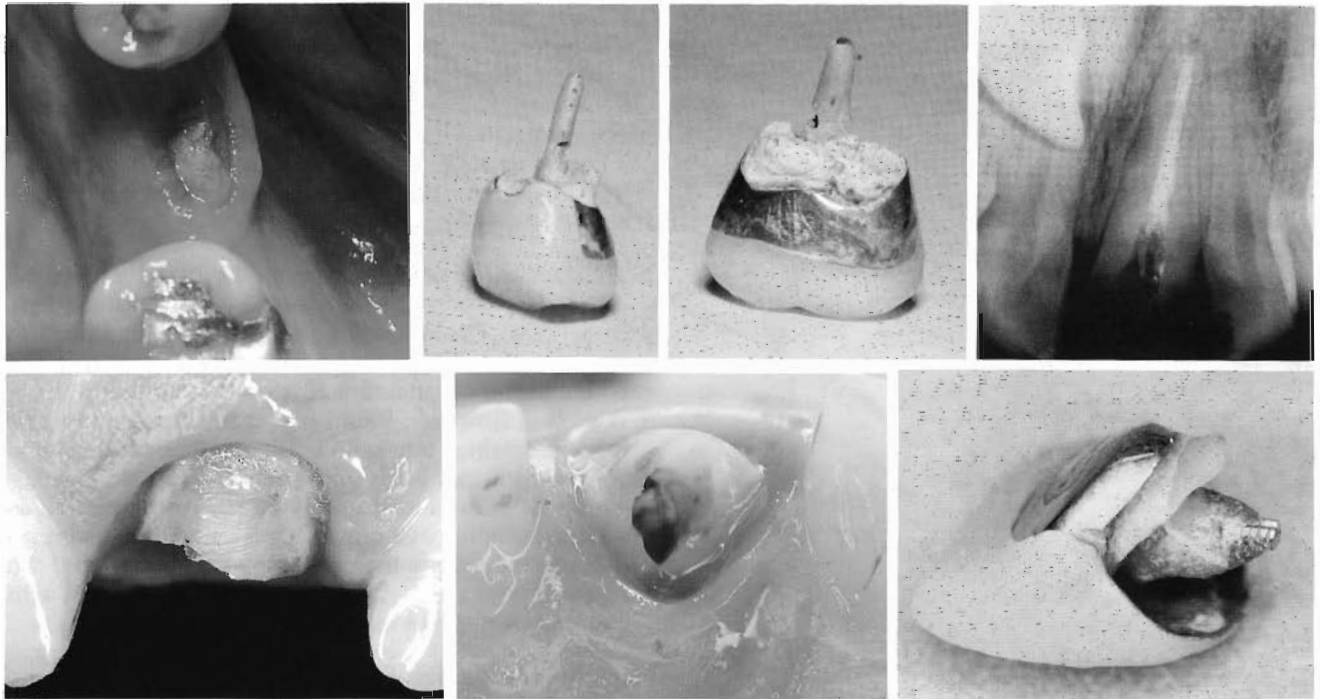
Top, The placement of coronal restoration margins on the build-up material should be avoided. Such an error combined with short post length is an invitation to tooth fracture (*left, second, and third panels*). Short posts concentrate stresses at the cervical zone, leading to tooth and root fracture. Preoperative radiograph (*right panel*). Bottom, Labial view (*left panel*). Lingual view (*middle panel*). Tooth crown fracture (*right panel*).
